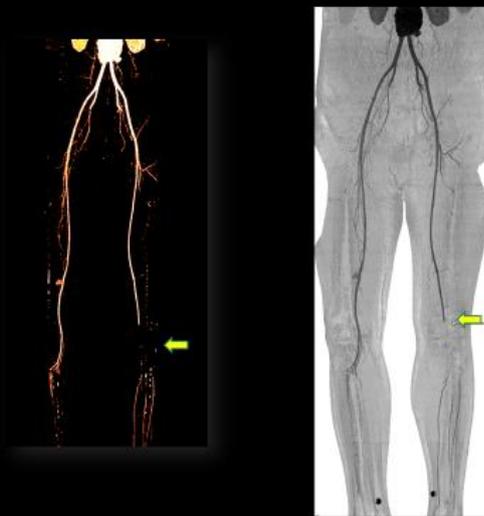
CT lower limb angio complete occlusion of left popliteal artery with refilling of anterior and posterior tibial arteries by collaterals .
